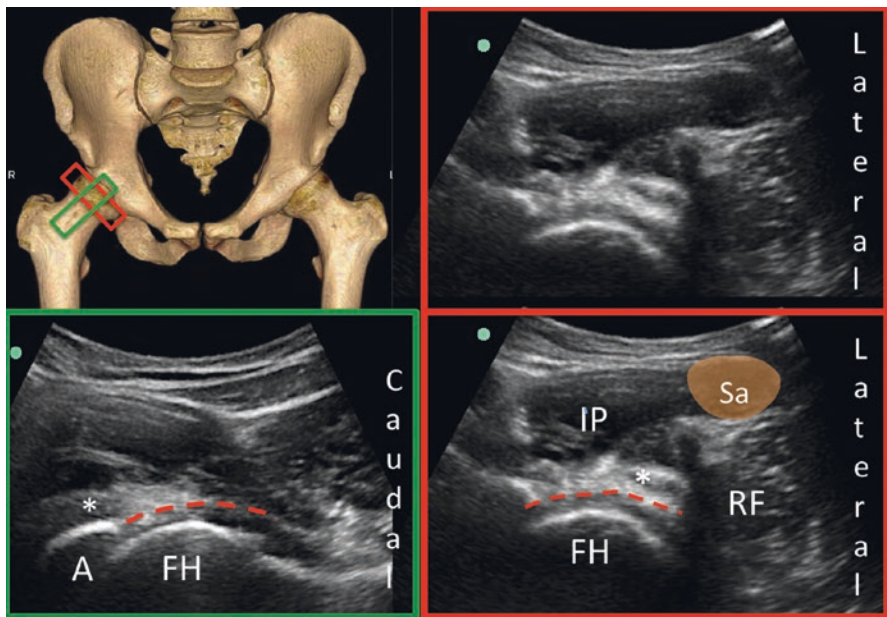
Sonographic image when the ultrasound probe was placed just distal to the pubic rami as in Fig. 27.6c. Upper left showed the position of the probe. Red rectangle represented the sonographic image on the right upper and lower images without and with label, respectively. The green rectangle is the long-axis view of the femoral head and neck and was shown in the lower left image. IP, iliopsoas; SA, satorius; RF, rectus femoris; *, psoas tendon; red dotted line, iliofemoral ligament. (Reprinted with permission from Philip Peng Educational Series)
